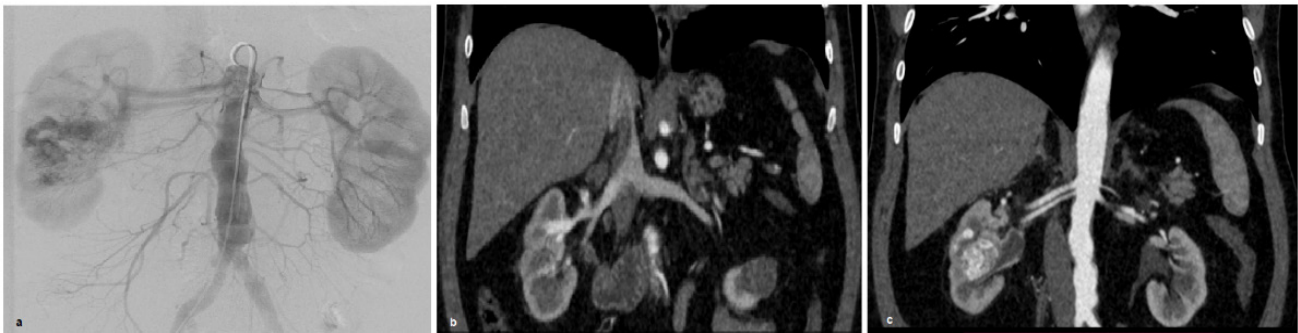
DSA and CT images obtained prior to treatment. 1a. DSA images obtained prior to endovascular embolization. 1b. and 1c. CT images obtained prior to treatment demonstrates enlarged renal veins and double renal arteries.
